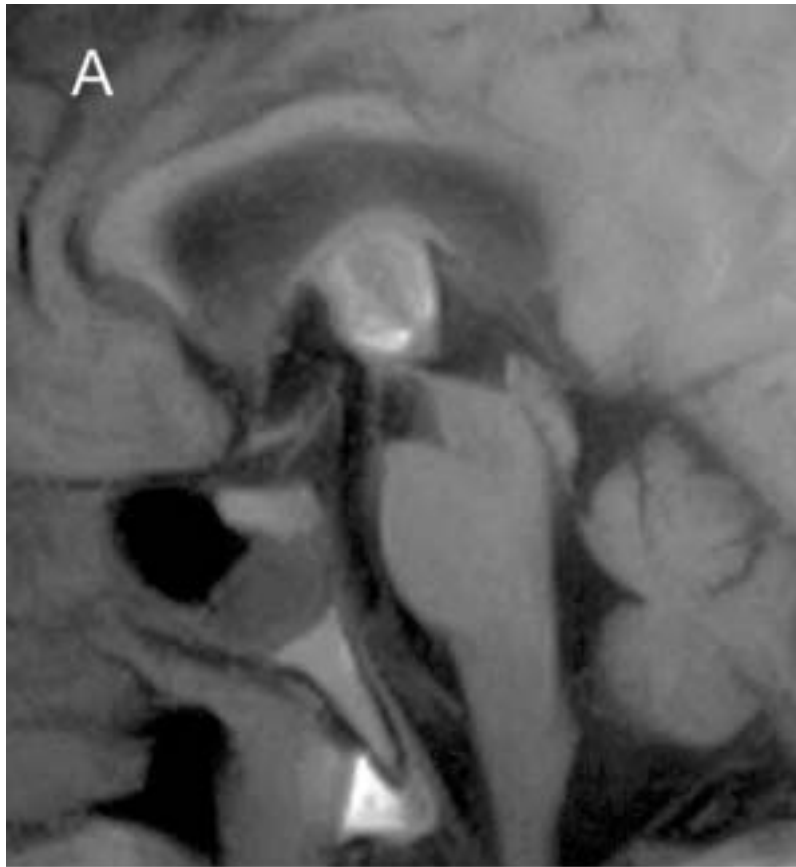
MR imaging demonstrating mildly enhancing third ventricular mass and non-communicating hydrocephalus. The mass appears to abut the basilar apex on the sagittal and coronal images. A: Sagittal T1-weighted pre-gadolinium MR image; B: coronal T1-weighted post-gadolinium images.
